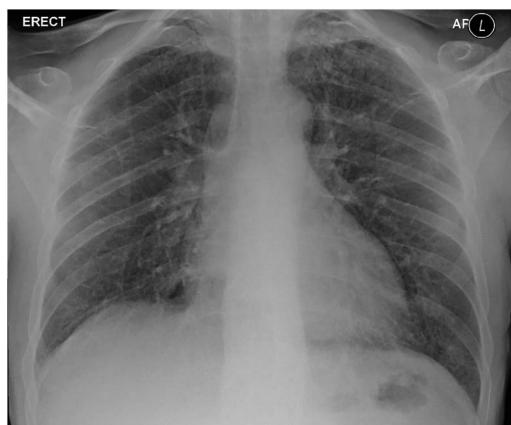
Chest X-ray depicting bilateral apical nodular alveolar opacities.
